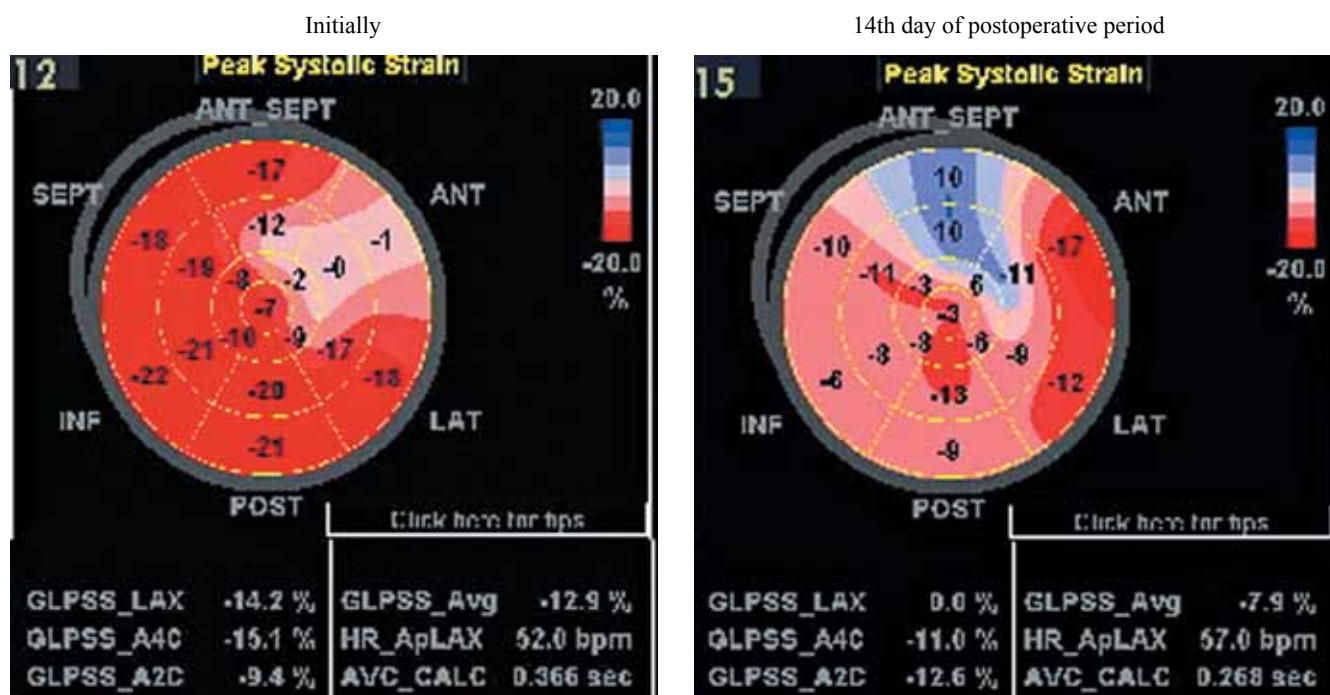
Dynamics of speckle tracking echocardiography (initially and on the 14th day of postoperative period)
